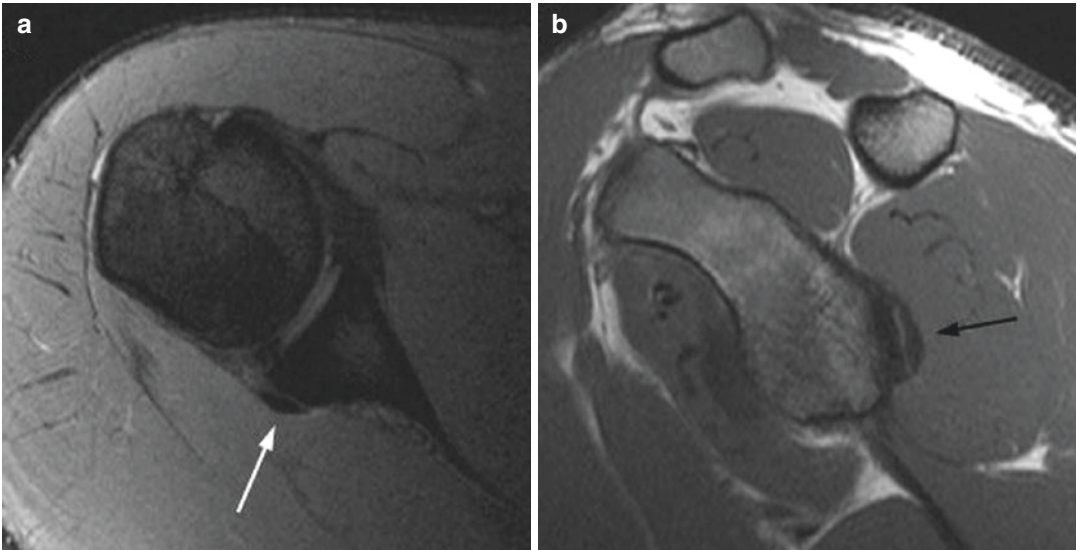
21-Year-old baseball pitcher with shoulder pain. (a) Axial gradient-echo and (b) sagittal T1-weighted images demonstrate a crescent-shaped focus of low signal
